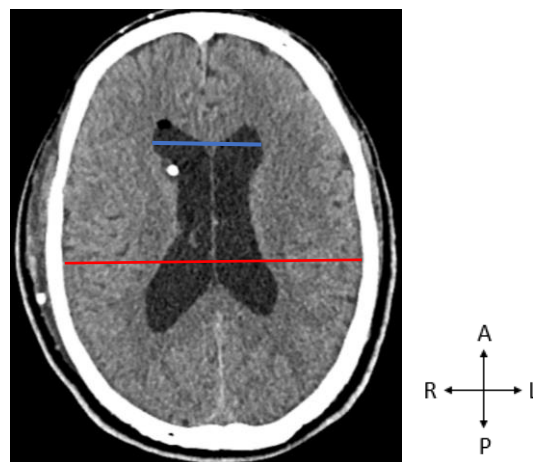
A CT scan of the brain in the axial view, indicating the bifrontal horn width (blue line) and the maximum inner cranial plate (red line). Image taken from the GSH PACS (20 October 2023). A - Anterior, R - Right, P - Posterior, L - Left.
